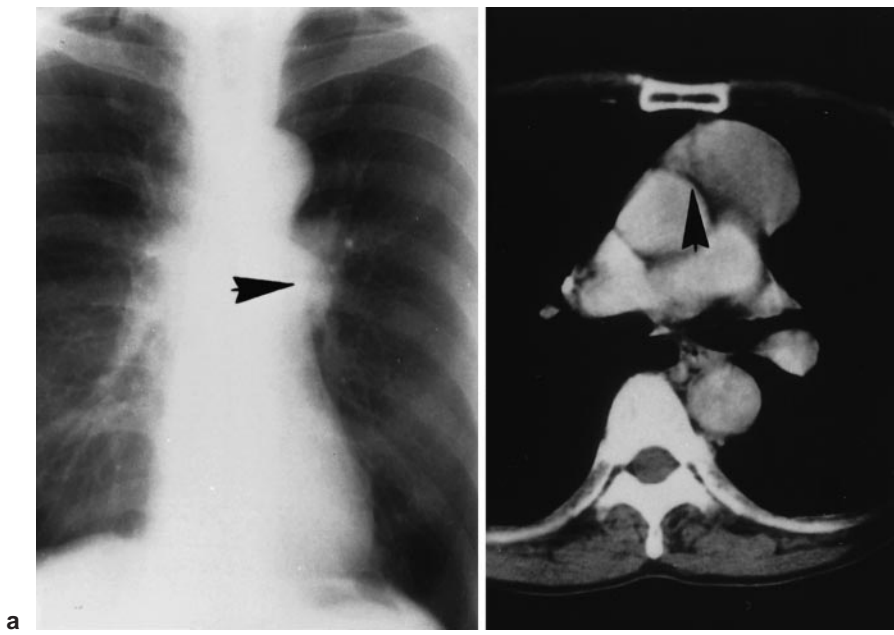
a Chest roentgenogram and b chest computed tomographic scan of case 2 show two masses (arrows) in the anterior mediastinum
